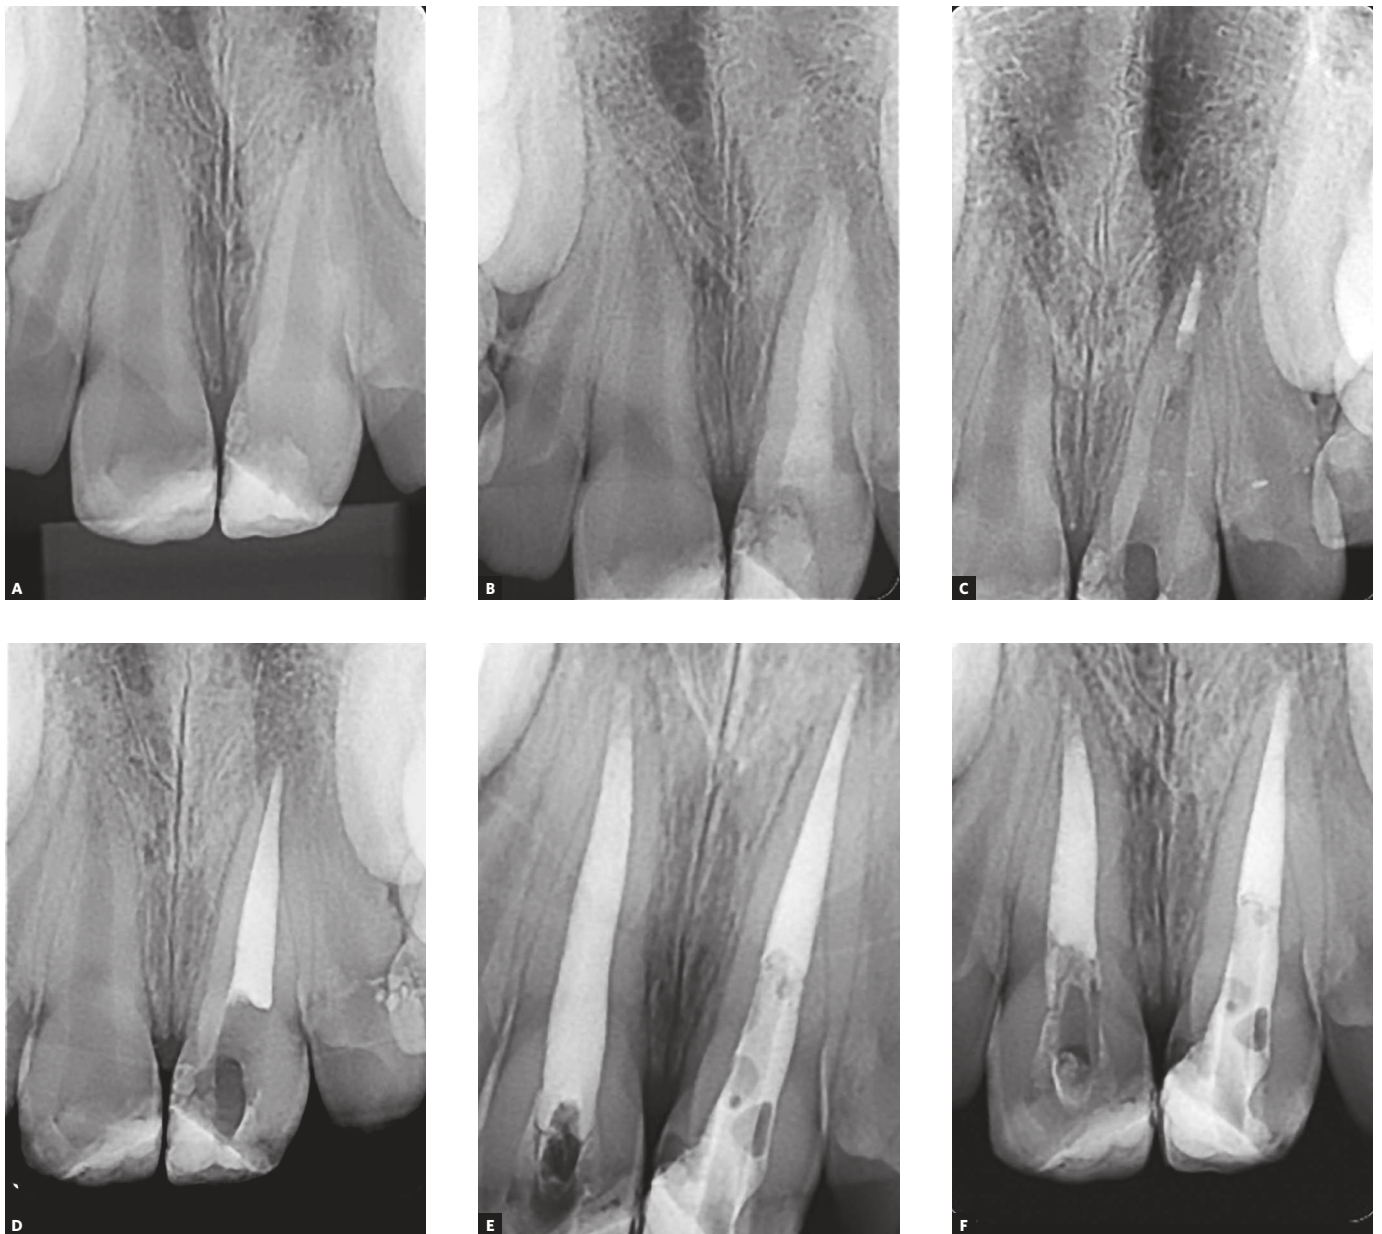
A) Periapical radiograph of maxillary central incisors with an open apex. B) Calcium hydroxide dressing in tooth #21. C) MTA plug in tooth #21. D) Final filling + MTA plug in tooth #21. E) Final filling + MTA plug in teeth #11 and #21. F) Radiographic control one year later.
